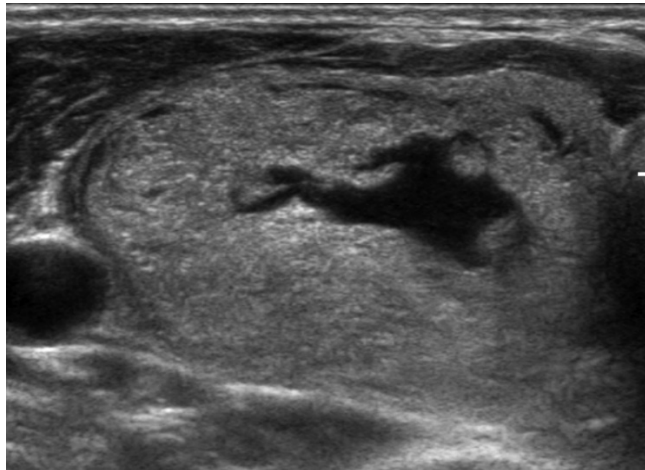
Transverse US image of a 50-year-old male with minimally invasive follicular thyroid carcinoma with wild type TERT showing a 5.8 cm predominantly solid nodule with smooth margin, isoechogenicity, and parallel orientation. This nodule was classified as K-TIRADS category 3 and ACR-TIRADS category 2. After surgery, the TNM stage was confirmed as I (T3N0M0) and there was no recurrence during 5 years of follow-up. US = ultrasound, TERT = telomerase reverse transcriptase, K-TIRADS = Korean-Thyroid Imaging Reporting and Data System, ACR = American College of Radiology, TNM = tumor, node, metastasis
